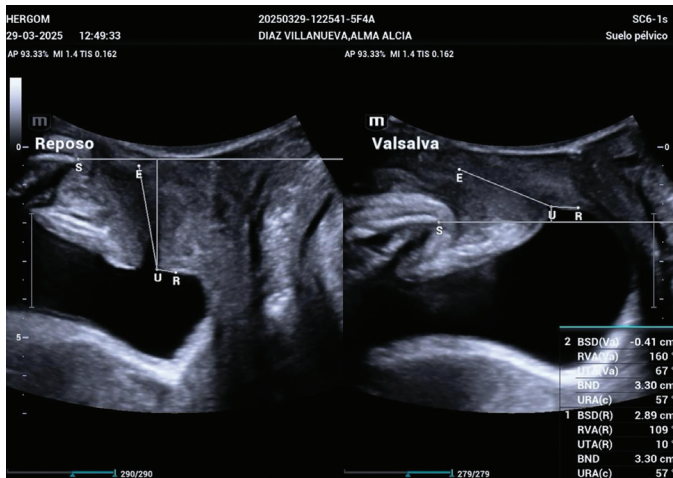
Ultrasonographic images of urethral mobility at rest and Valsalva prior to surgery
